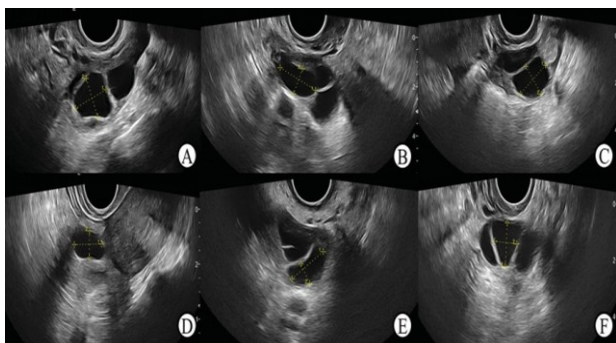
In contrast to 20–36 follicle ultrasound photos, 5–10 ultrasound images of the leading follicle were obtained from each cycle prior to ovulation during the single follicle monitoring.
